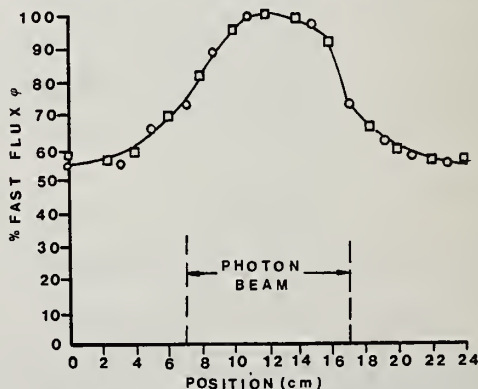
Percent fast neutron flux versus position for  $10 \times 10 \text{ cm}$  25 MV X-ray beam based on phosphorus activation (  $\circ$  = in plane of electron orbit,  $\square$  = perpendicular to electron orbit).
